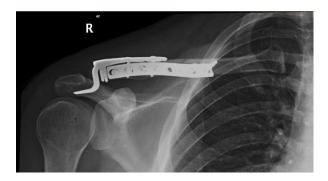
AP view plain radiograph of the right clavicle following open reduction and internal fixation with anterior clavicle plate and a hook plate.
